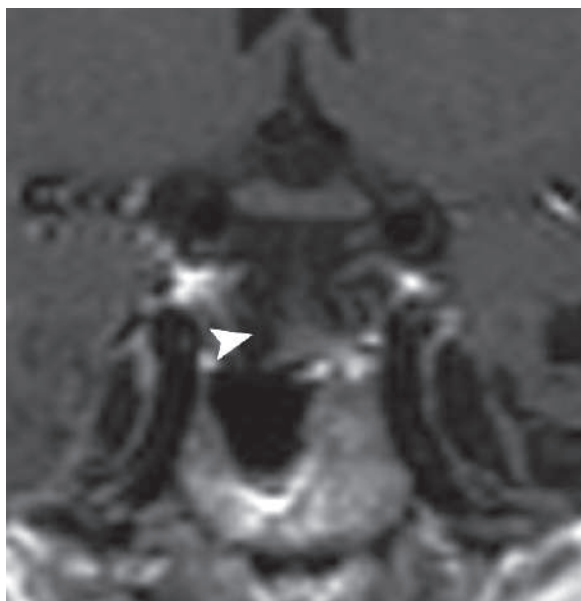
Coronal nonenhanced MRI of the sella shows marked reduction of the sellar mass (*arrowhead*), with the pituitary stalk seen dipping in the sella beyond the level of the posterior clinoid process (*empty sella*)
